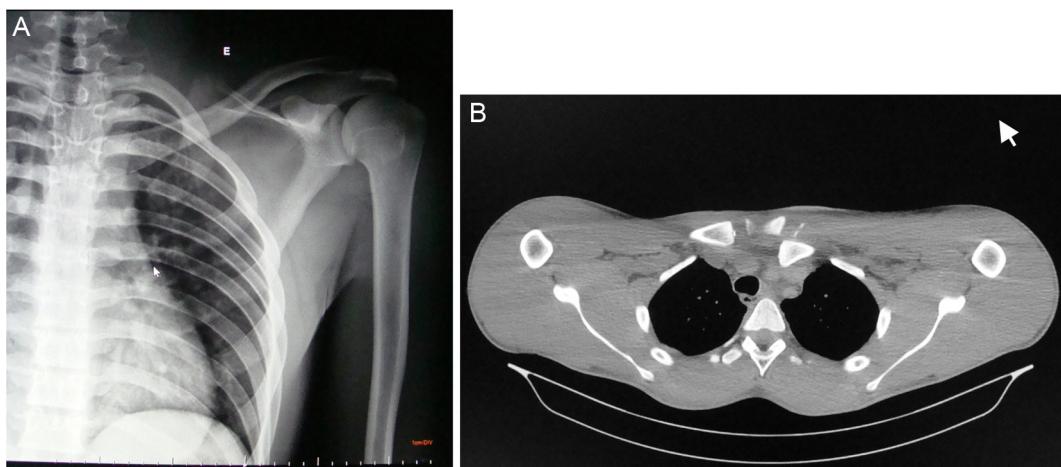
(A) Radiography after closed reduction; (B) computed tomography showing recurrent dislocation.
